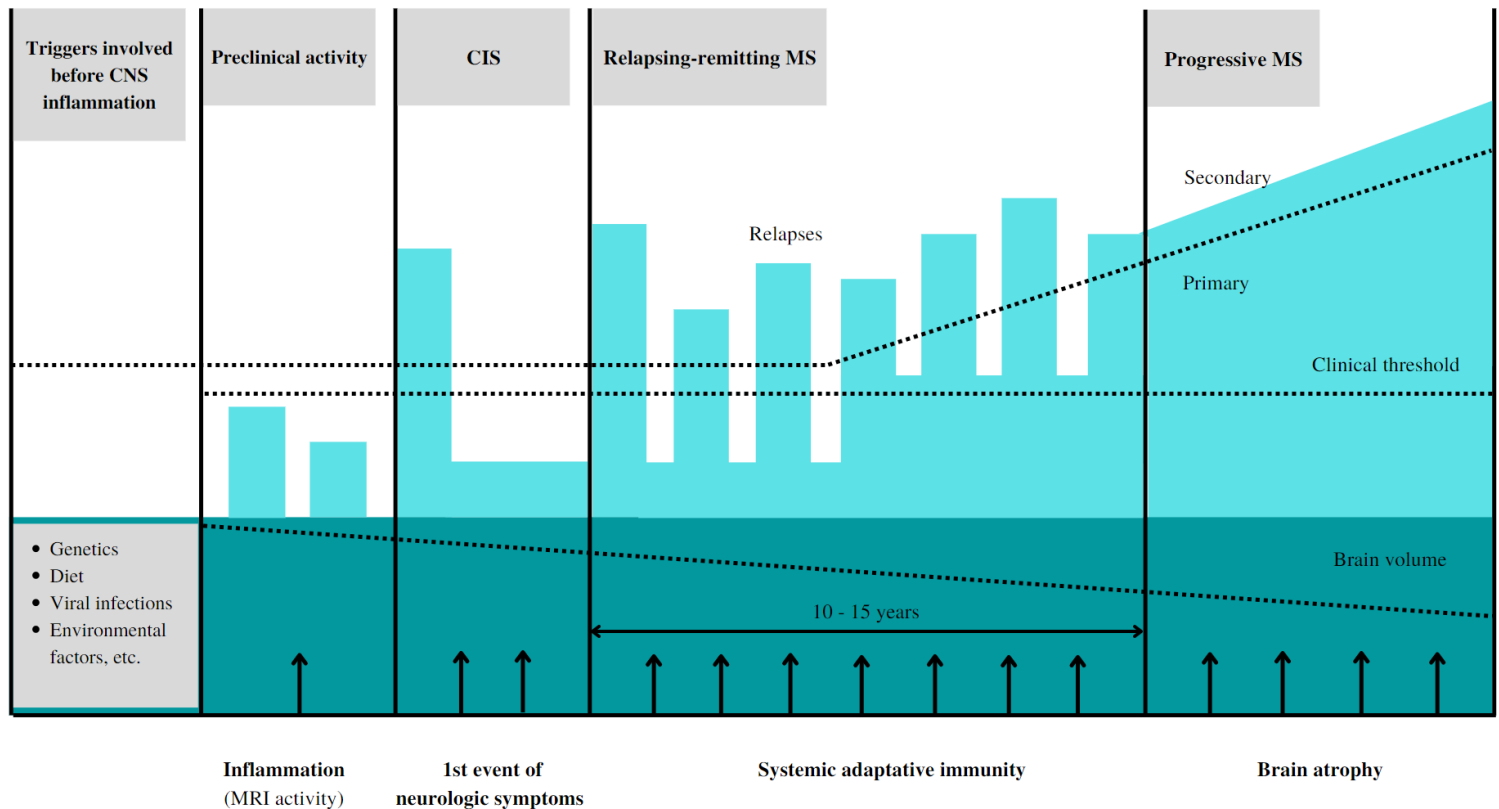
Different stages in Multiple Sclerosis. MS begins long before it is detected by MRI; this episode is known as clinically isolated syndrome (CIS). It is the first stage characterized by neurological symptoms for at least 24 hrs. Then it progresses to an Relapsing remitting MS (RRMS) stage characterized by relapses that may last for several years (10-15 years). Finally, a patient reaches the progressive stage of MS characterized by loss of brain volume and evident brain atrophy. Adapted from: (Baecher-Allan et al., 2018, Olsson et al., 2016).
